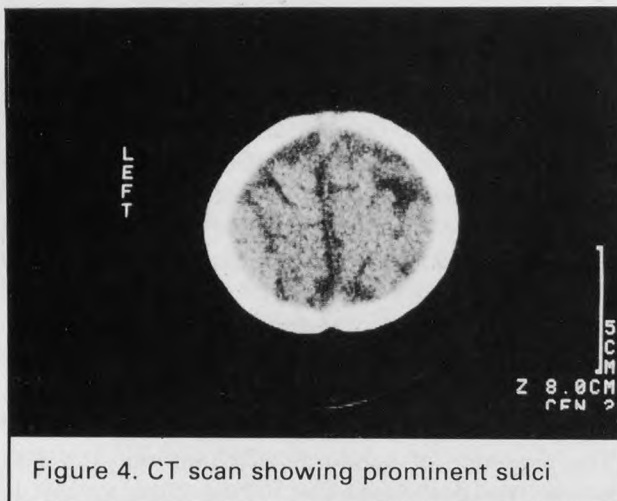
CT scan showing prominent sulci
